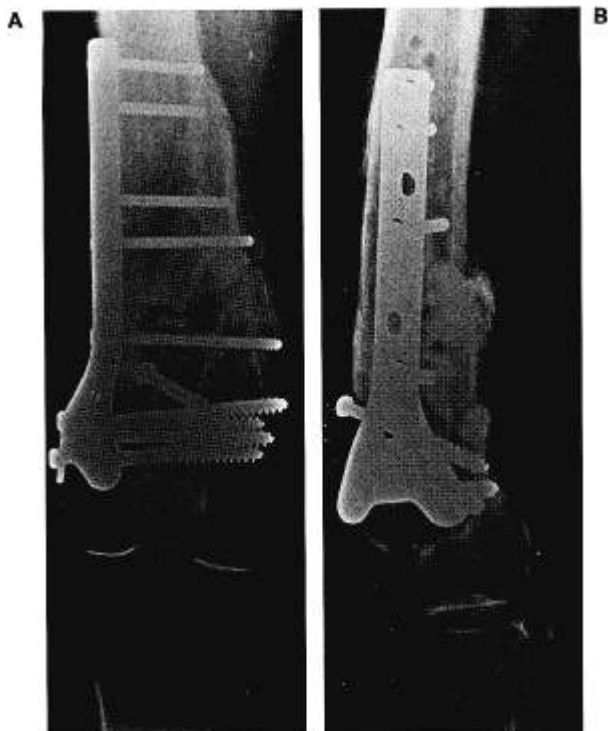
(A) AP and (B) lateral radiographs of condylar buttress tension band plate osteosynthesis of distal femur nonunion at 8 months. Anteroposterior lag-screw fixation reduces posterior displacement of femoral condyles. No bone graft was used on this hypertrophic nonunion. There is slight valgus deformity of the distal femur with mild shortening secondary to previous treatment.
